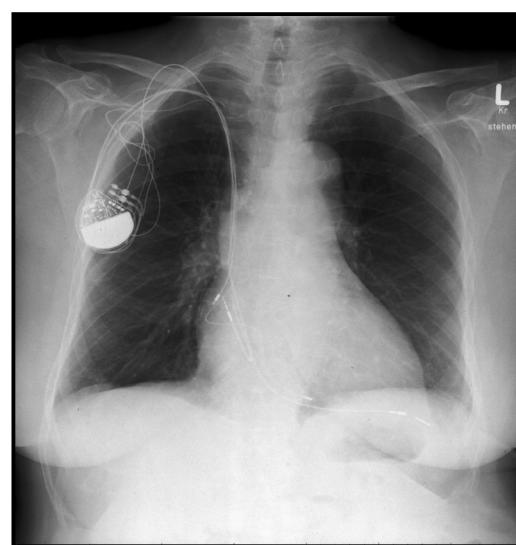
Posteroanterior chest radiograph of the patient showing the ventricular lead beyond the cardiac silhouette.
